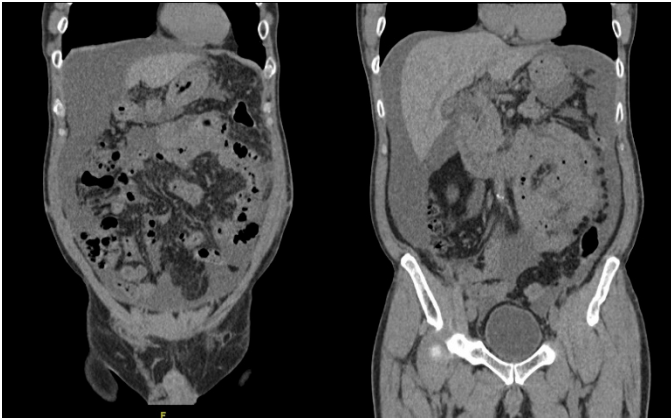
Non-contrast CT KUB revealed moderate ascites with diffuse peritoneal thickening. No evidence of hydro-ureteronephrosis.
